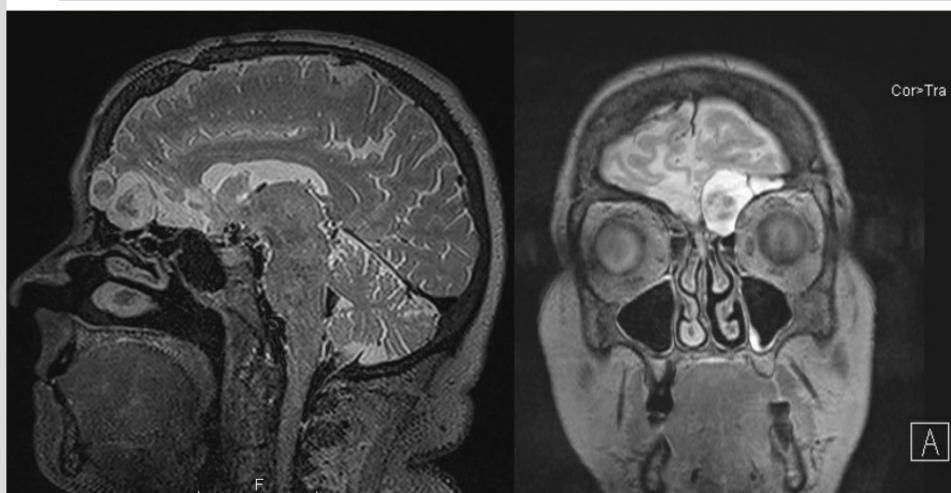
T2 sagittal and coronal MRI showing left sided frontal sinus fluid collection remodeling of the sinus walls
